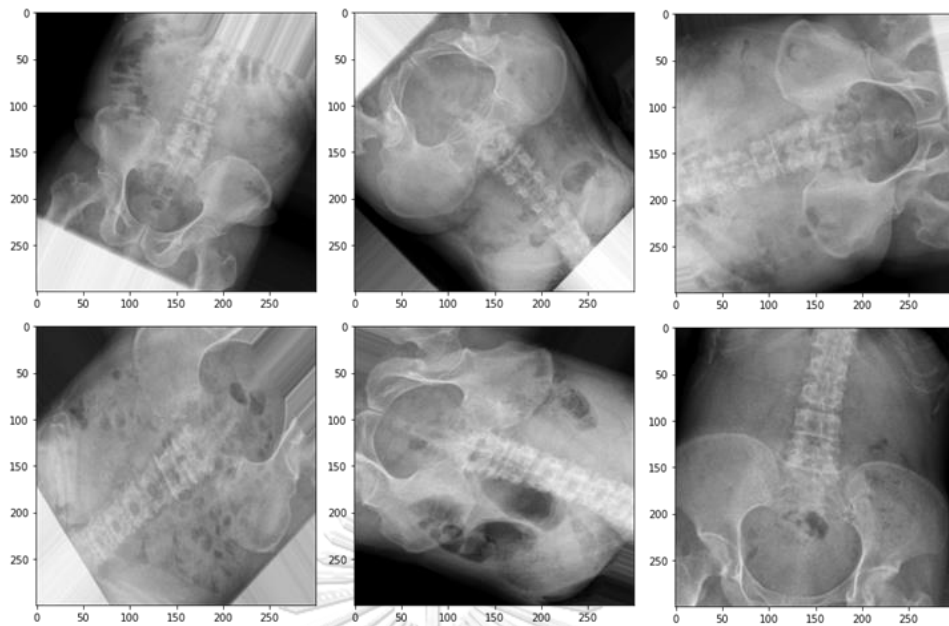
Examples of augmented abdominal radiographs
